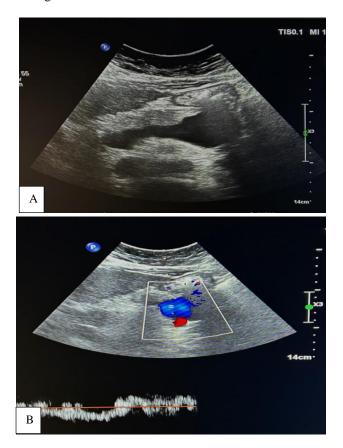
(A and B): USG: A-showing cystic lesion in pancreas. B-cystic lesion showing venous waveform in doppler.
